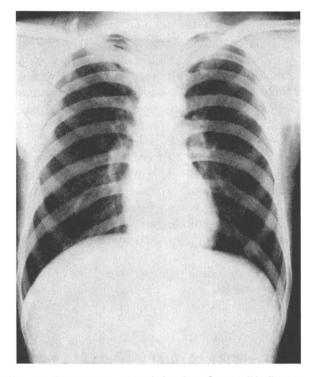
A roentgenogram of the chest from a "dry" case.
